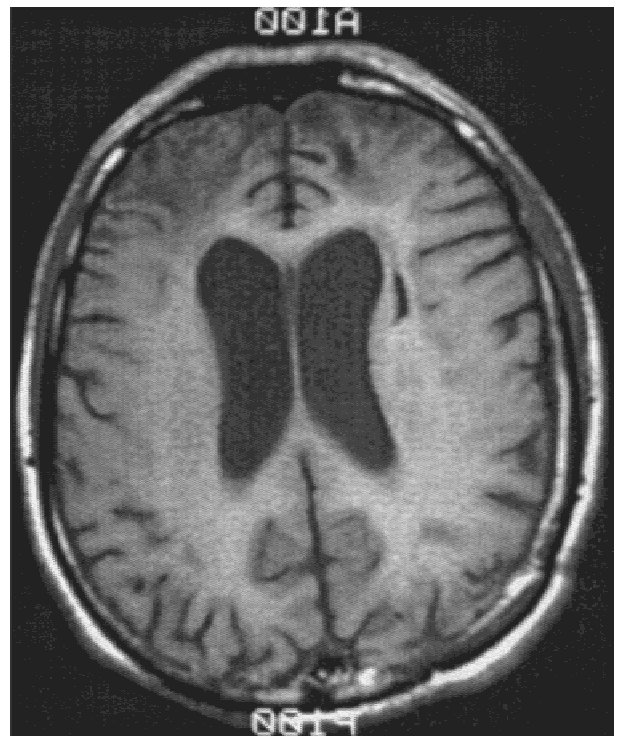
Day-of-injury (DOI) computed tomography (CT) scan (19-Jan-90) in a trauma victim (fall of some 30 feet). Note the presence of skull fracture in the posterior right quadrant (scans are presented with the patient's left on the viewer's left). Adjacent to the DOI scan is a follow-up MR scan (14-Nov-94) several years postinjury that demonstrates ventricular dilation, cortical atrophy, and a lesion adjacent to the right body of the lateral ventricle. These pathological changes are typical of severe trauma to the brain and can be quantified, as depicted in the histogram presented in Figure 8.
